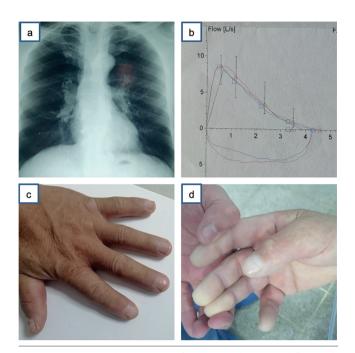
a) Normal chest X-ray from 2017. b) Normal flow-volume curve. c) Patient's hand showing sclerodactyly. d) Raynaud's phenomenon was evidenced during the bronchoscopy.
